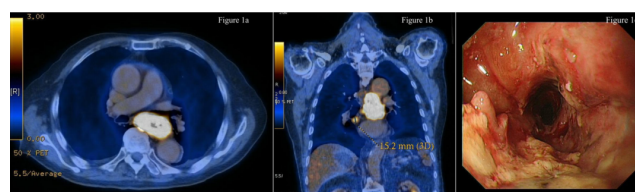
(a) PET-CT (transverse section) showing uptake in mid-thoracic esophagus. (b) PET-CT (coronal reconstruction) showing regional lymphadenopathies. (c) upper endoscopy showing mid esophagus irregular growth occupying more than 50% of circumference.
